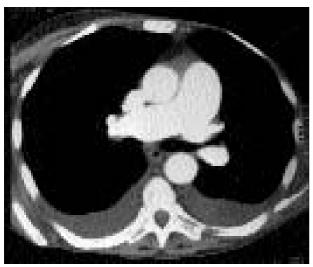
High resolution computed tomography (CT) scan with injection showing prominence of the main pulmonary arteries and bilateral pleural effusion. No mediastinal lymph nodes are seen on this section.
